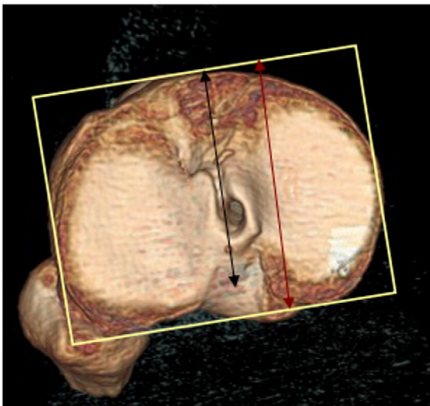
The variations in the shape of the tibia affect the measurements. The dark line represents the mid-sagittal depth of the tibia used for CT and MR images, which are single slices. The red line represents the depth used when measuring on X-ray and CT-mip images, which are summation images.
